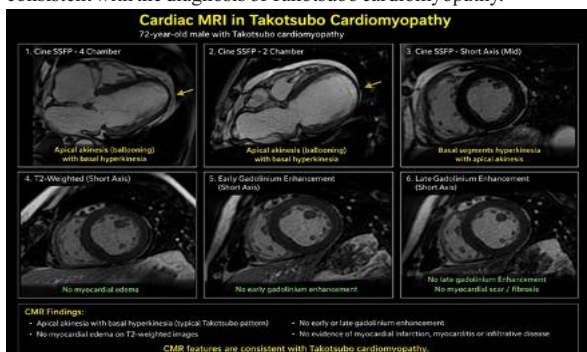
Cardiac MRI confirming features consistent with takotsubo cardiomyopathy
